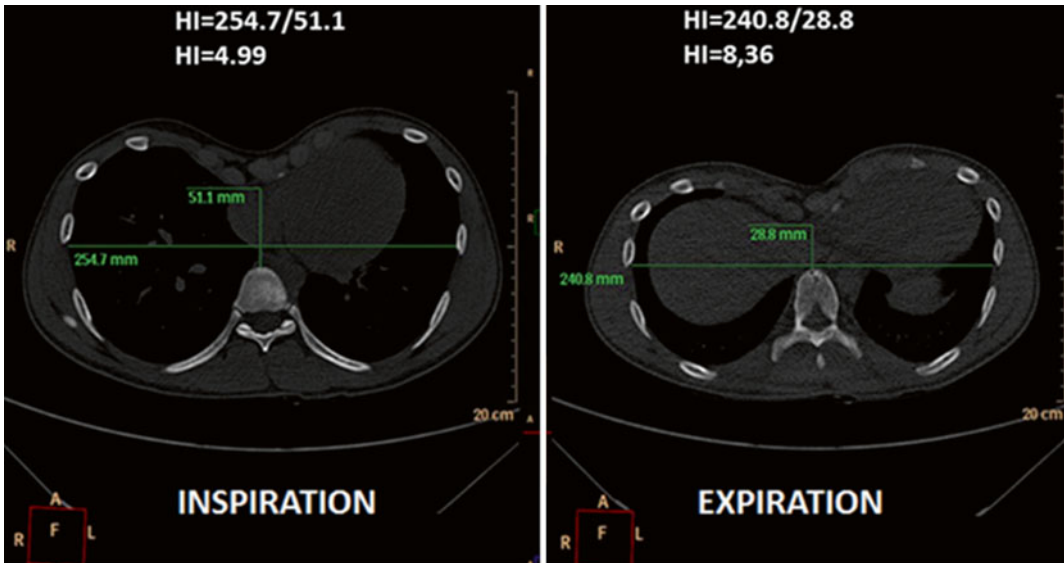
Chest CT Scan of a 16-year-old PE patient. Axial CT images of the same patient are observed at full inspiration and full expiration. Demonstration of measurements performed to assess PE. A significant reduction
